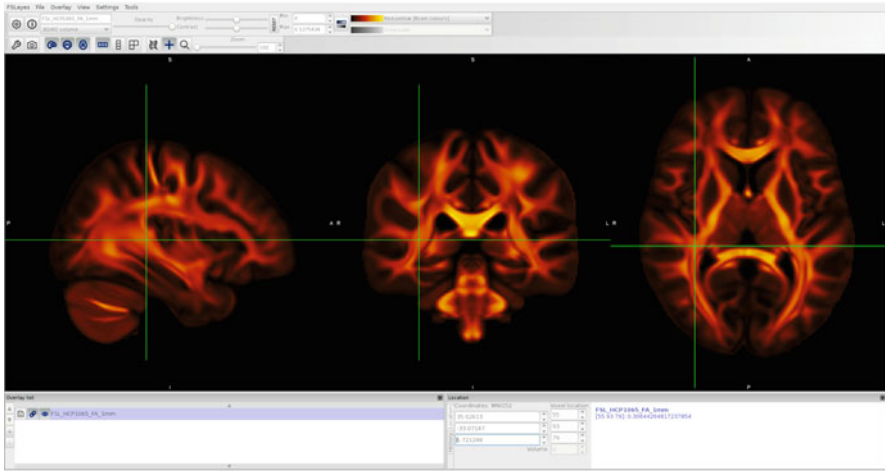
Visualization of white matter tracts obtained after analyzing diffusion-weighted MRI. (These are anisotropy maps, whereby the color intensity is proportional to the fractional anisotropy which is an estimate of neural fiber density)
